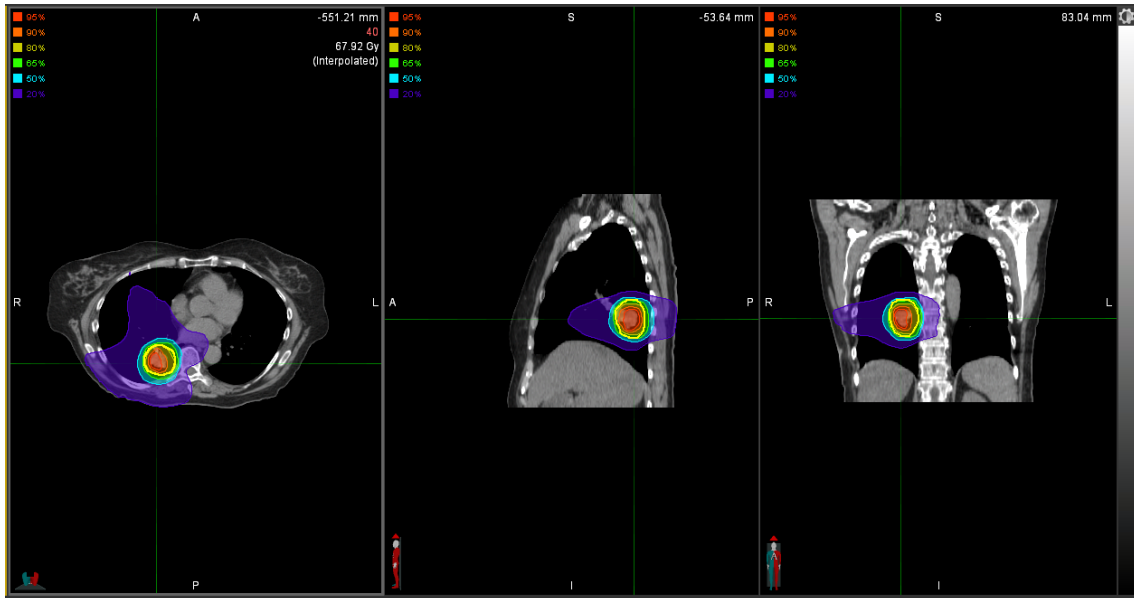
The reference phase CT for patient 5, accumulated dose overlaid with the PTV outlined in yellow.
